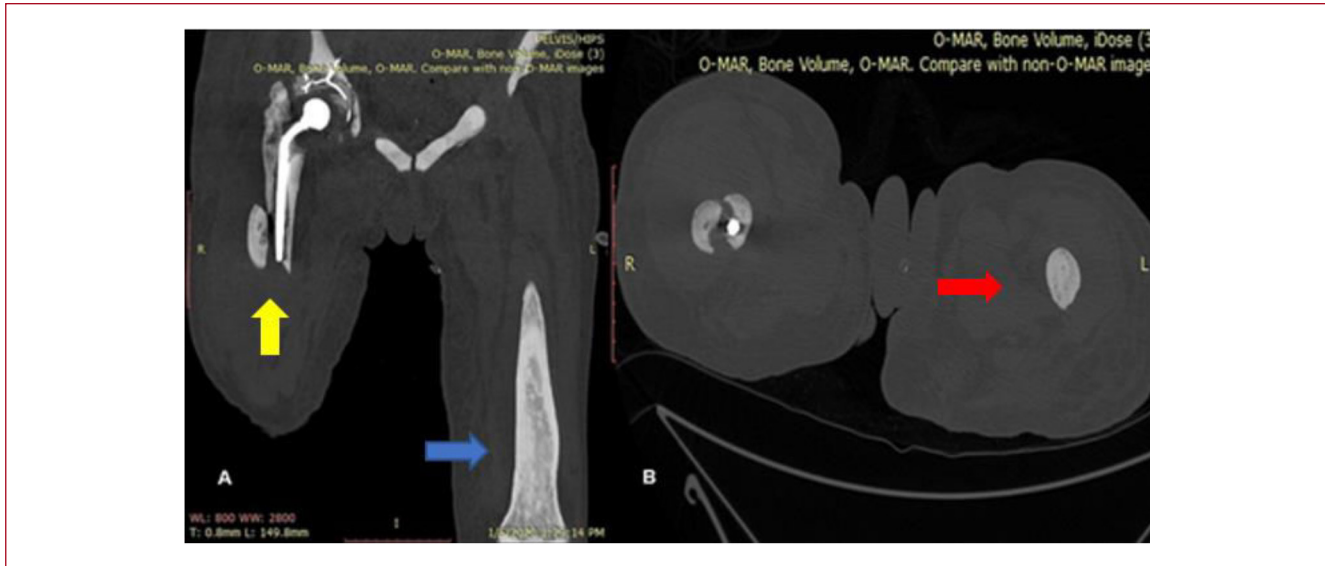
CT scan depicting a periprosthetic fracture of the right femur (yellow arrow), obliterated medullary canals (red arrow) and the characteristic Erlenmeyer flask deformity of the distal femur (blue arrow). A. coronal view, B. axial view.
